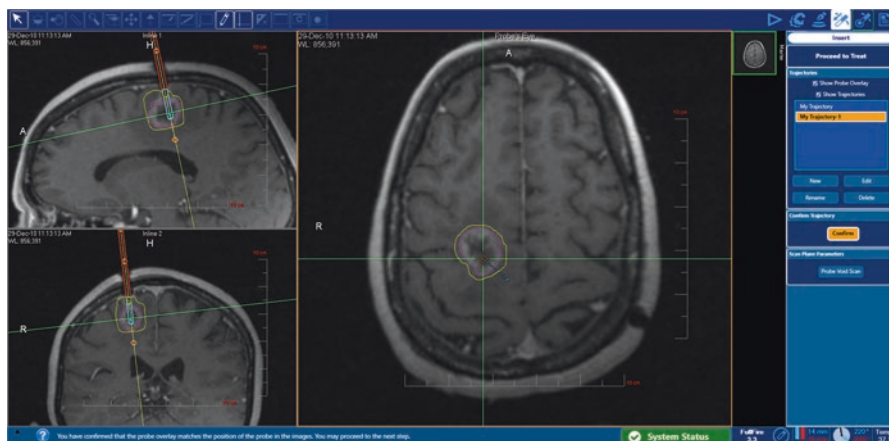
The location of the laser probe confirmed by intraoperative MRI (near vertical pair of red and blue lines)
